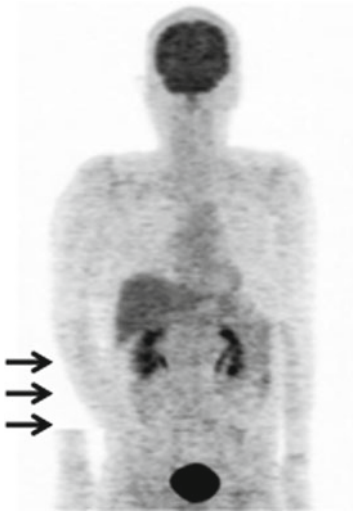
FDG PET MIP image shows an unusual appearance with discontinuous activity in the right forearm (*arrows*) as a result of patient's movements between bed scan positions
